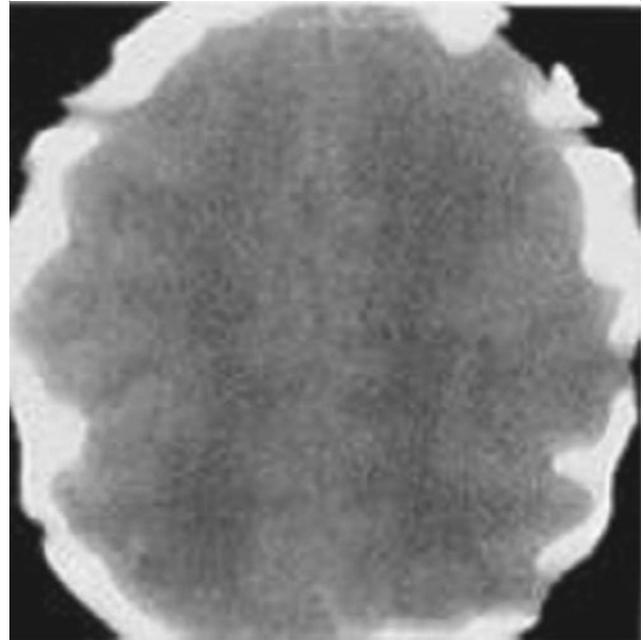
Computed tomographic scan of a Chiari 2 malformation. Note the prominent craniolacunia.
